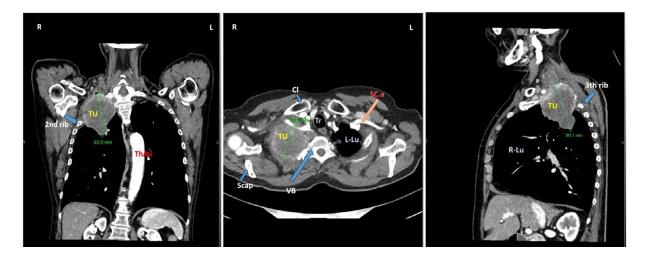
CT examination: coronal, transversal, and sagittal section. Cl- clavicula, L-Lu – left lung, R-Lu – Right lung, SC.a – subclavian artery, Sca – scapula, ThAo- Thoracic aorta, Tr – trachea, TU – tumor, VB – vertebral body.
